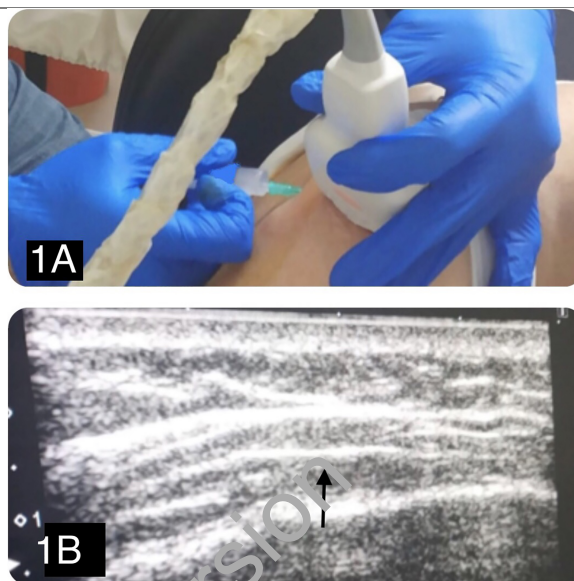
A: Ultrasound-guided subacromial postero-lateral injection. B: Ultrasound image of an in-plane lateral to-medial approach of a 21 gauge needle (arrow) placement.
